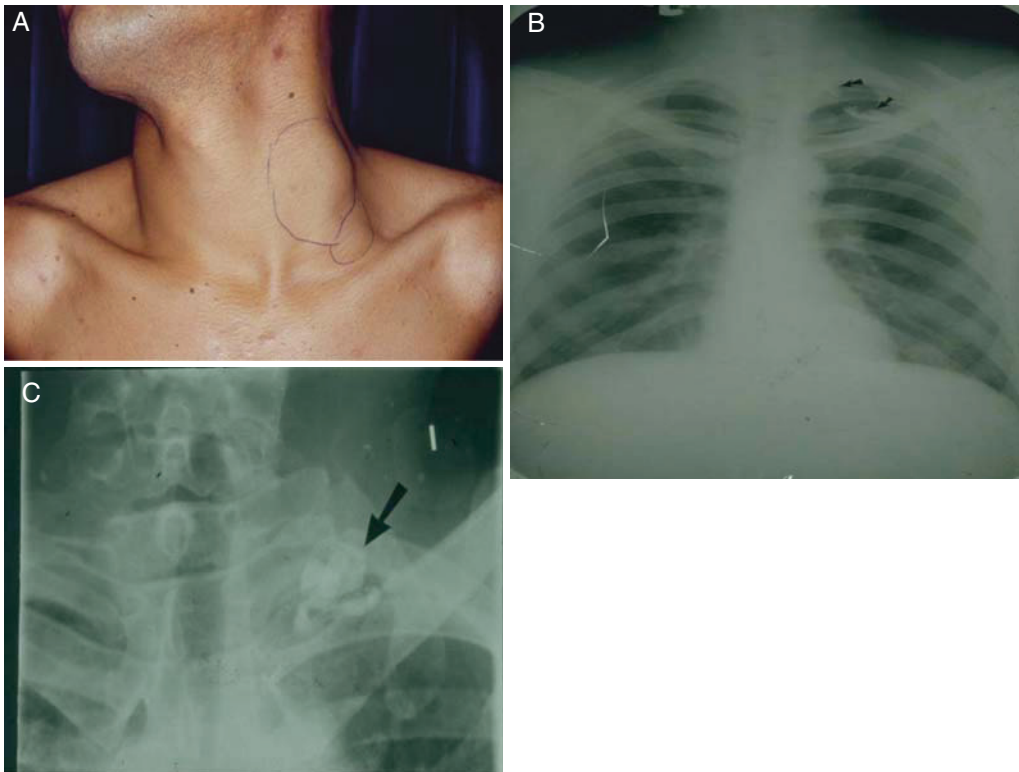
(A) Palpable lymph nodes left supraclavicular area (photography). (B) Chest X-ray. Arrows indicate supraclavicular SLN after testicular lymphangiogram. (C) Close detail of the supraclavicular SLN after testicular lymphatic injection.
